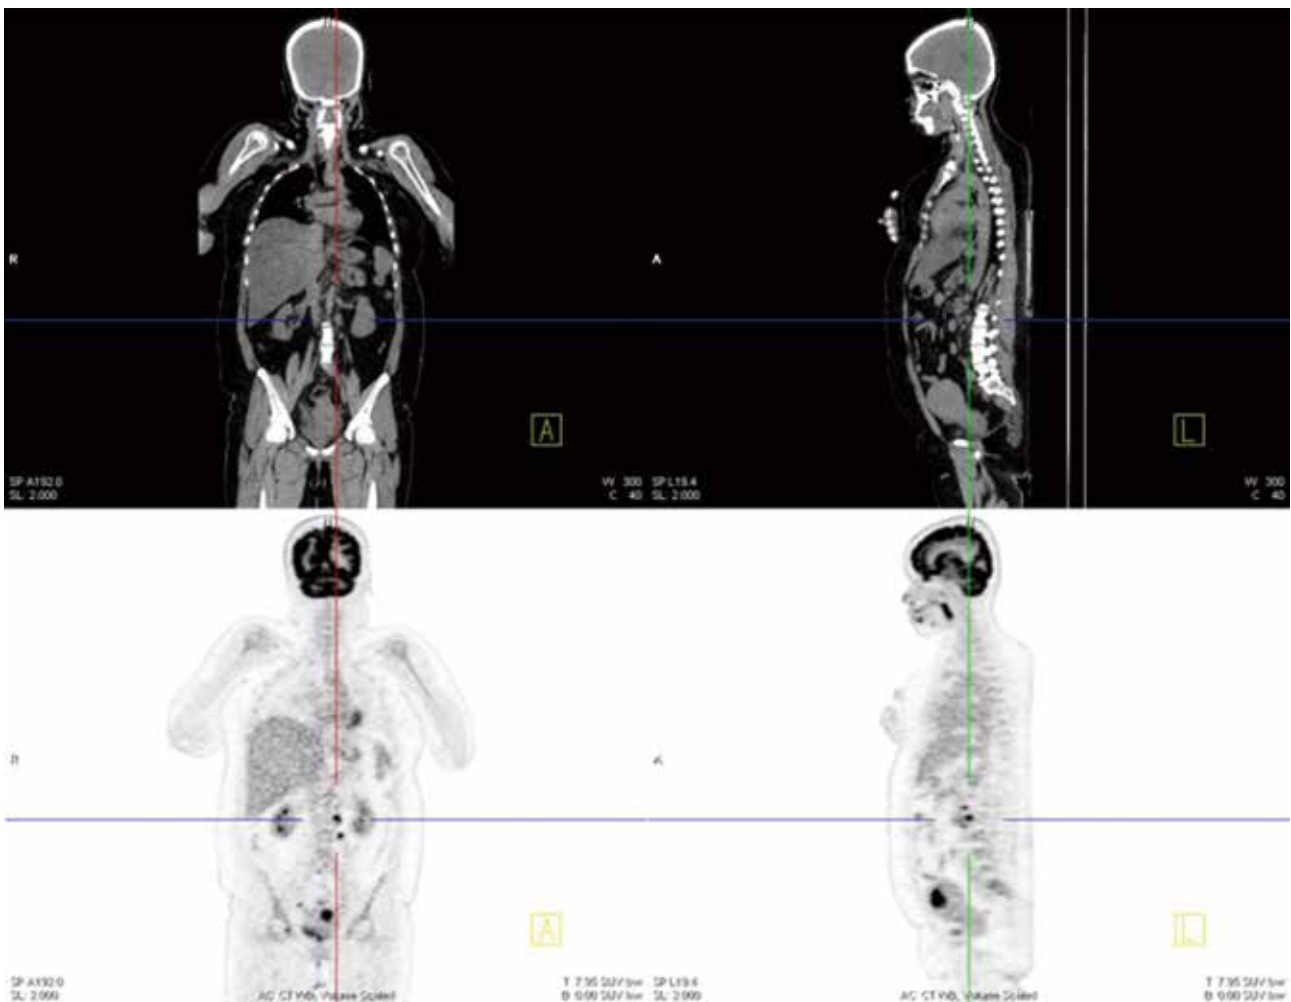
^{18}F -FDG PET/CT 發現子宮頸癌遠端淋巴結轉移
